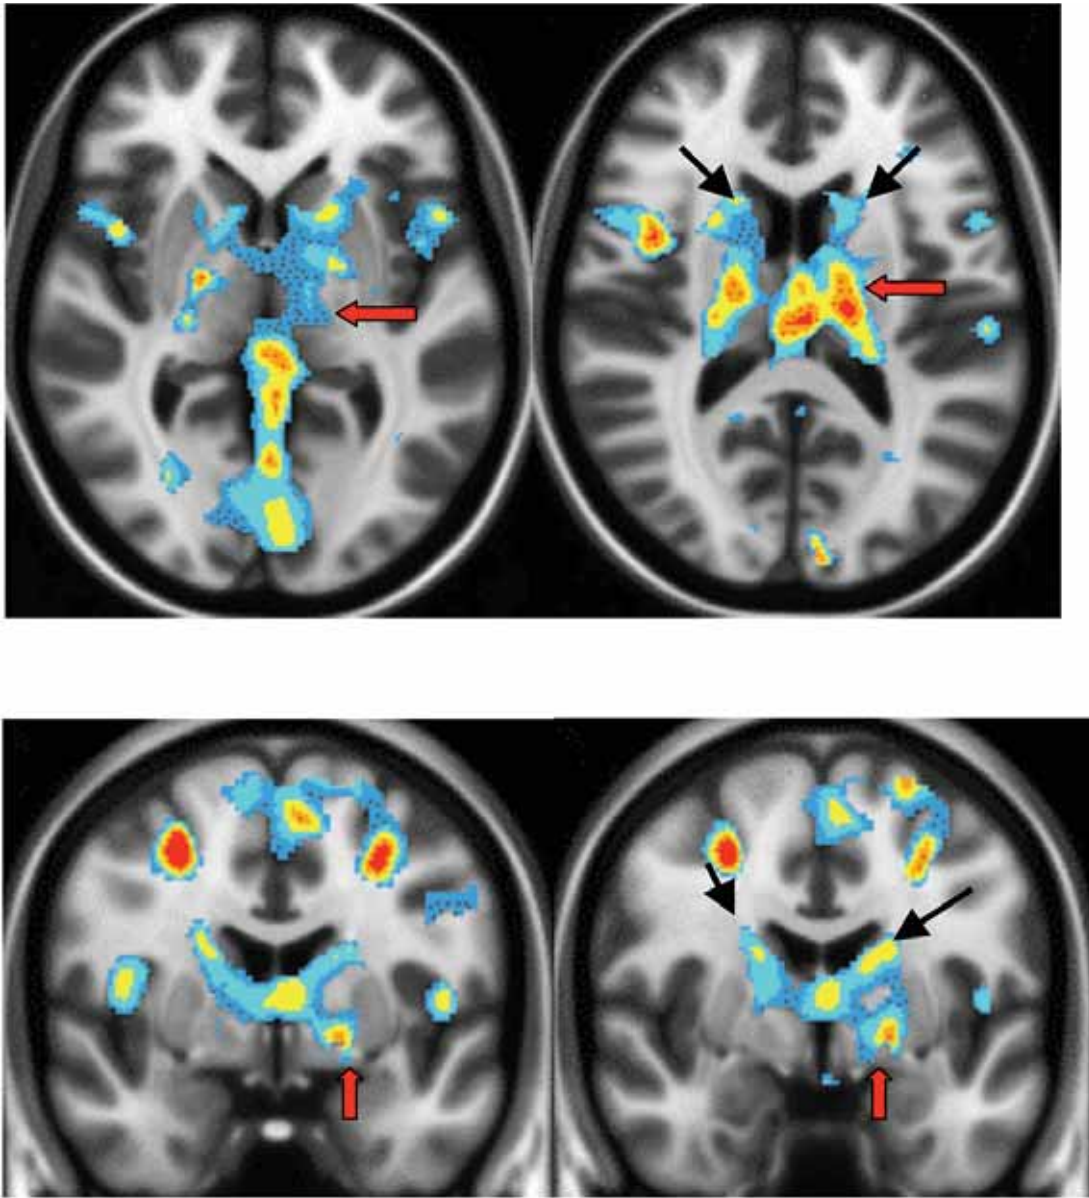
Color overlays on axial (A) and coronal (B) views of T1-weighted images at the basal ganglia and thalamic regions. Intensity of activation was displayed as color, gradual change from dark blue (less activity) to red (strong activity). The pictures showed activities at the bilateral caudate nuclei (black arrow) and left thalamus (red arrow).
